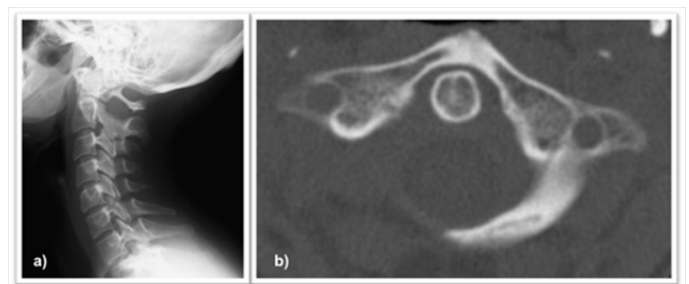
a) Lateral radiograph of the cervical spine revealing a thin posterior arch of the atlas; b) CT-scan (axial) showing a posterior arch defect of the atlas in its right portion.
